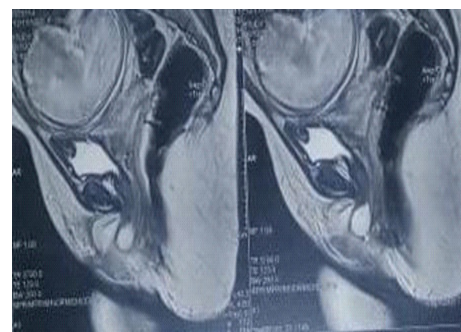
Sagittal section of MRI in T2 sequence showing the precise location of the urethral diverticulum.
